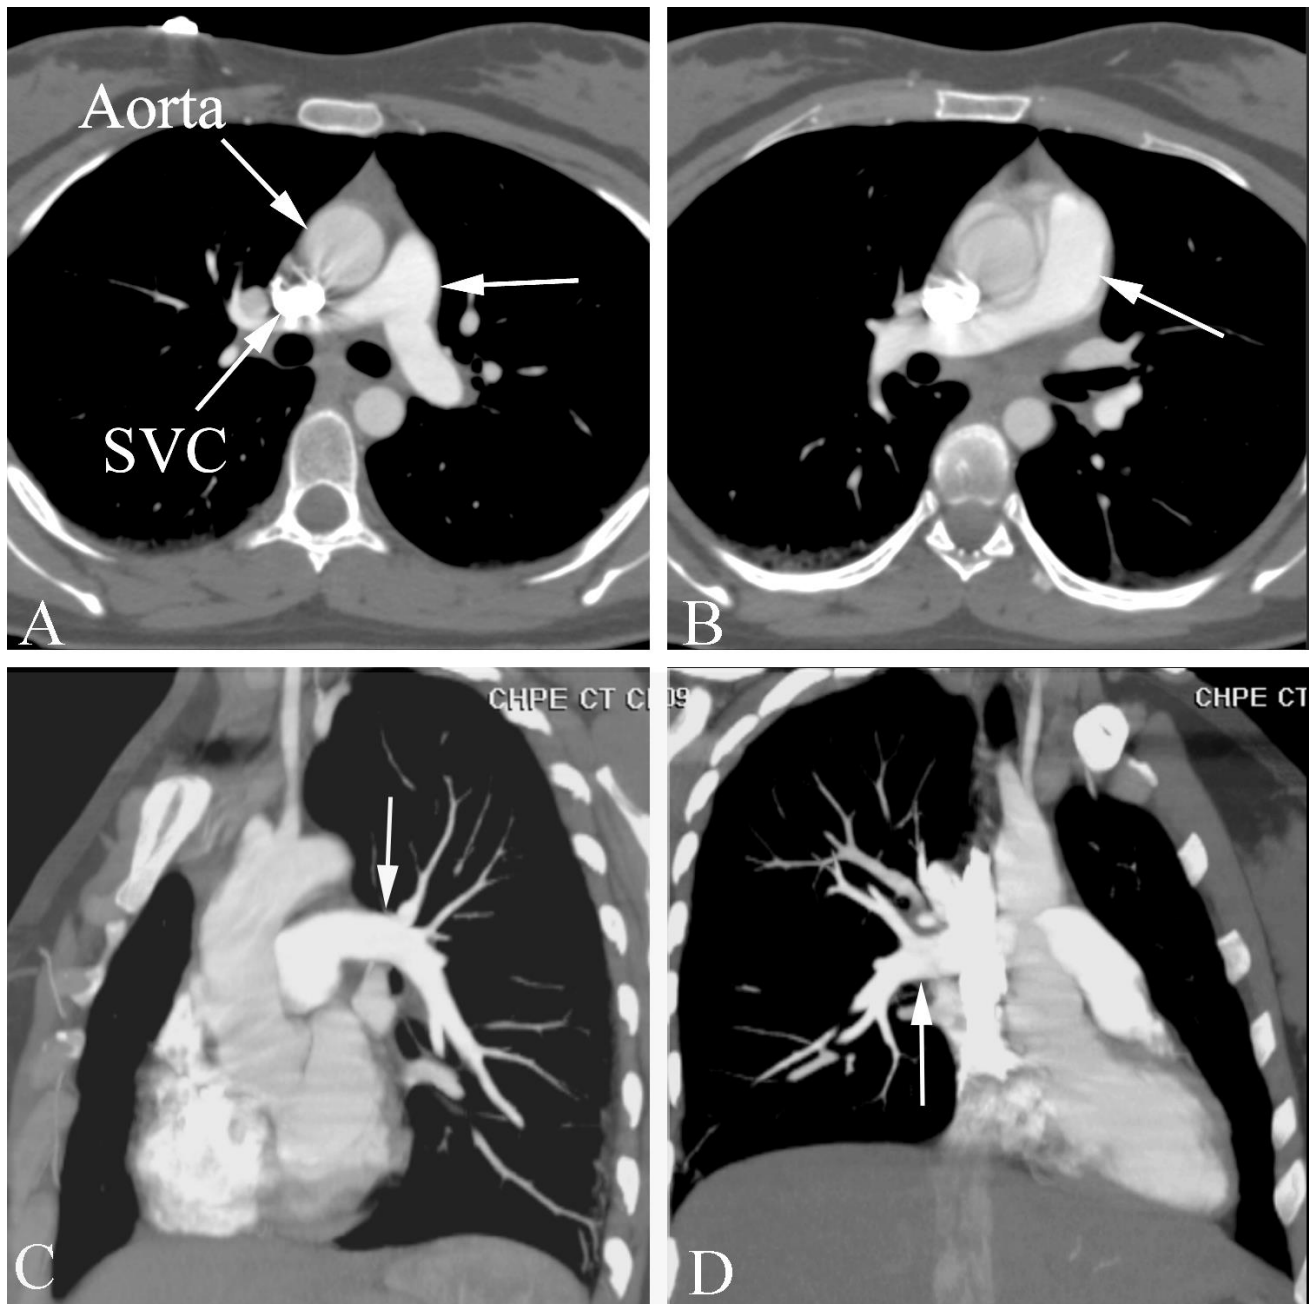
Normal chest CT angiogram in a 28 year old woman with acute chest pain. A. Axial contrast-enhanced CT study at the level of the main pulmonary artery (arrow) shows a normal appearance of the pulmonary artery. Note dense contrast coming into the heart through the superior vena cava. B. Axial contrast-enhanced CT at a slightly lower level shows that the main pulmonary artery (arrow) is approximately the same size as the ascending aorta. C. Coronal oblique reformatted contrast-enhanced CT study shows the left pulmonary artery (arrow) and branches to be free of filling defects. D. Coronal oblique reformatted contrast-enhanced CT study shows the right pulmonary artery (arrow) and branches to be free of filling defects as well.
